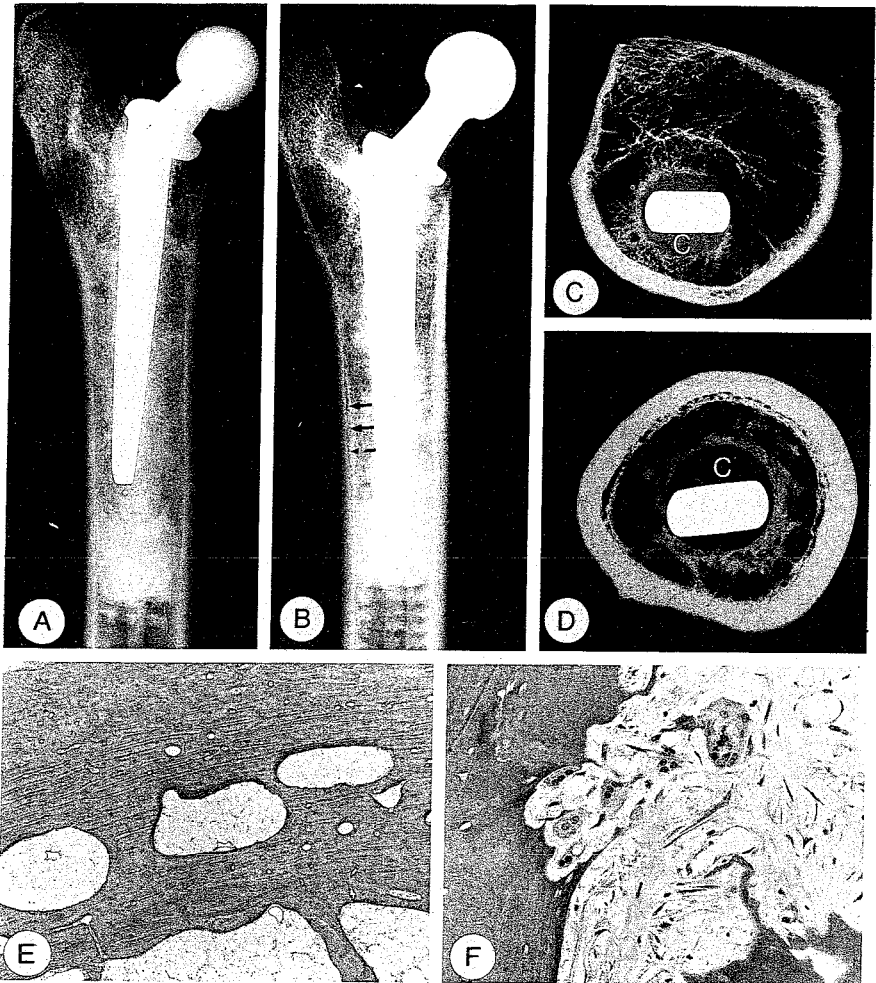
A and B The prostheses after 6 and 12 weeks, respectively. Note in A the change in trabecular appearance between the lateral proximal and more distal regions around the prosthesis. B. Locally, a radiolucent reactive line is present in the cortical bone (arrows). C and D Roentgenograms of thick sections of the proximal (C) and mid-shaft levels (D) of the femur after 12 weeks. Note the orientation of the trabeculae from the cement layer (C) to the preexisting cortical host bone. E Cortical porosis, $\times 30$. F Local osteoclastic resorption of the graft. Note empty osteocyte lacunae, $\times 250$.
